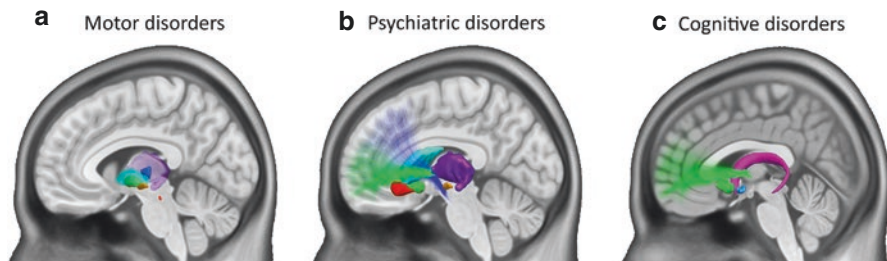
Common DBS targets. 3D representation of brain targets overlaid on sagittal MRI (T1-weighted standard Montreal Neurological Institute brain). Apart from the caudate nucleus, only targets which have been investigated with molecular neuroimaging are displayed (Tables 46.1, 46.2, 46.3, 46.4, 46.5, 46.6, and 46.7). (a) Motor disorder targets: the globus pallidus externa (light blue), globus pallidus internus (green), pedunculopontine nucleus (red), subthalamic nucleus (yellow), thalamus (purple), and ventral intermediate nucleus of the thalamus (dark blue). (b) Psychiatric disorders targets: the caudate nucleus (light blue), middle forebrain bundle (dark blue), subgenual cingulate gyrus (red), subthalamic nucleus (yellow), thalamus (purple), and ventral capsule/ventral striatum and relevant tracts (green). (c) Cognitive disorder targets: the fornix (pink), nucleus basalis (blue), and ventral capsule/ventral striatum and relevant tracts (green)
